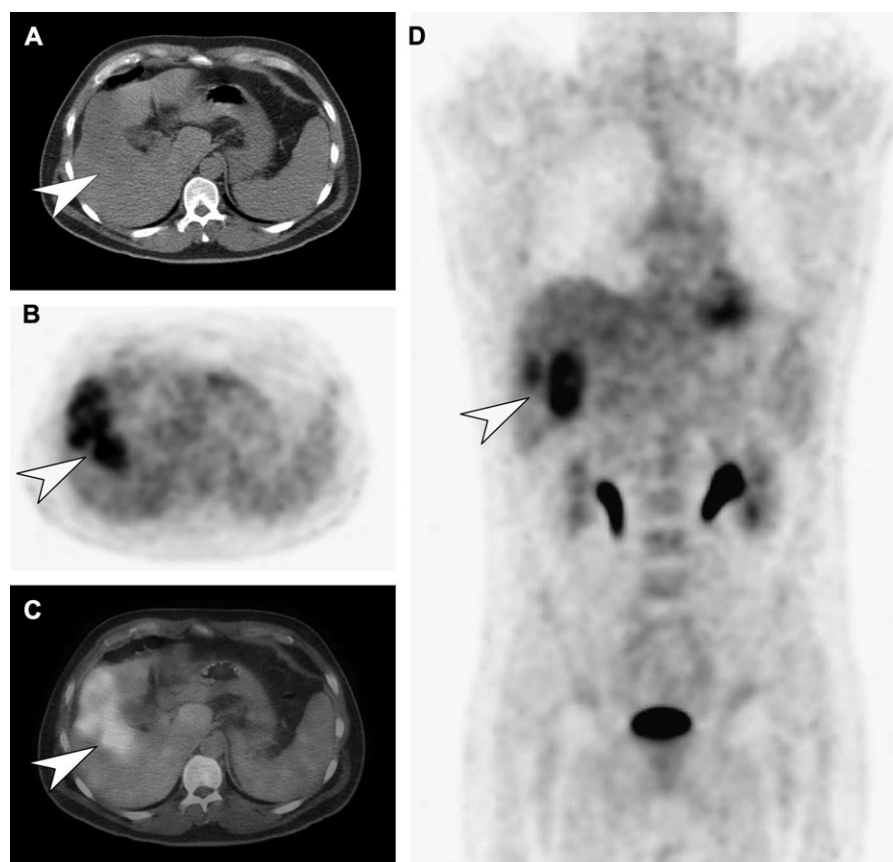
Pre-operative assessment prior to liver metastasectomy. Isolated liver metastasis (arrow) in the right lobe seen on CT (A), confirmed on transaxial FDG-PET (B) and integrated FDG-PET/CT (C) images. No extrahepatic disease was seen on whole body coronal FDG-PET (D), which demonstrated normal uptake in the myocardium, kidneys and urinary bladder.
